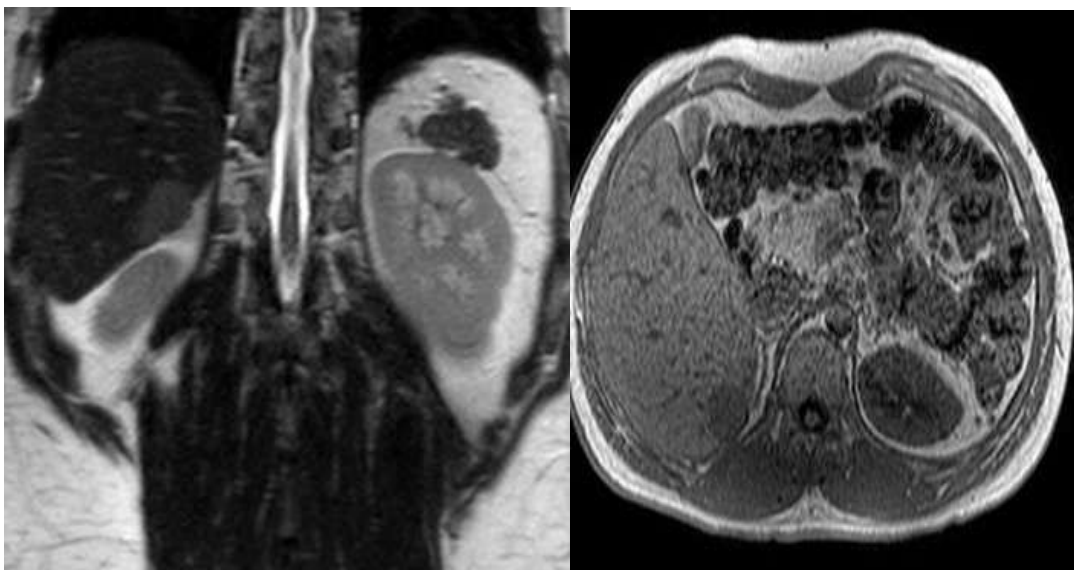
MRI T1 and T2 weighted images shows well-demarcated T1 hypointense and T2 hyperintense peripheral subcapsular lesion .
